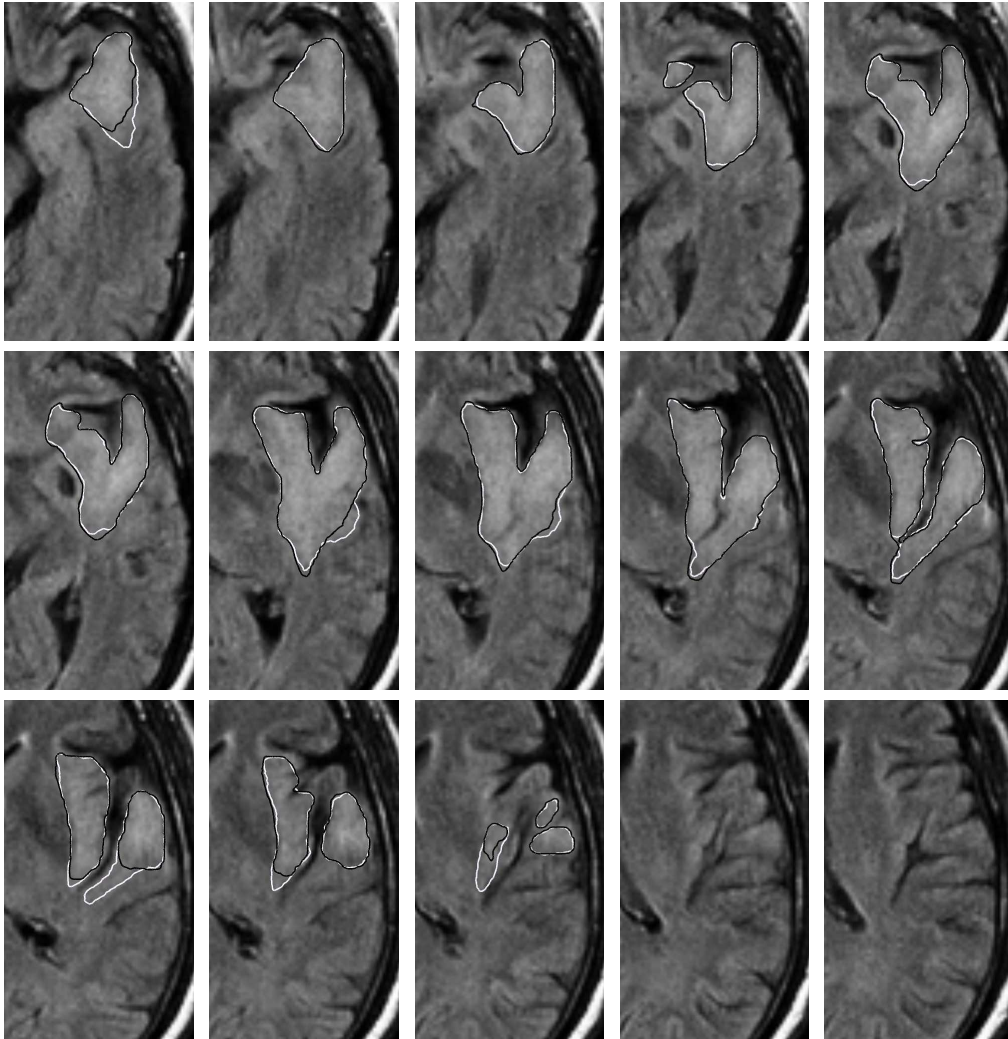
The MR image taken at the second time point for the second patient. The white contour denotes the manual delineations and the black contour is the estimated evolution of the tumor delineation.
